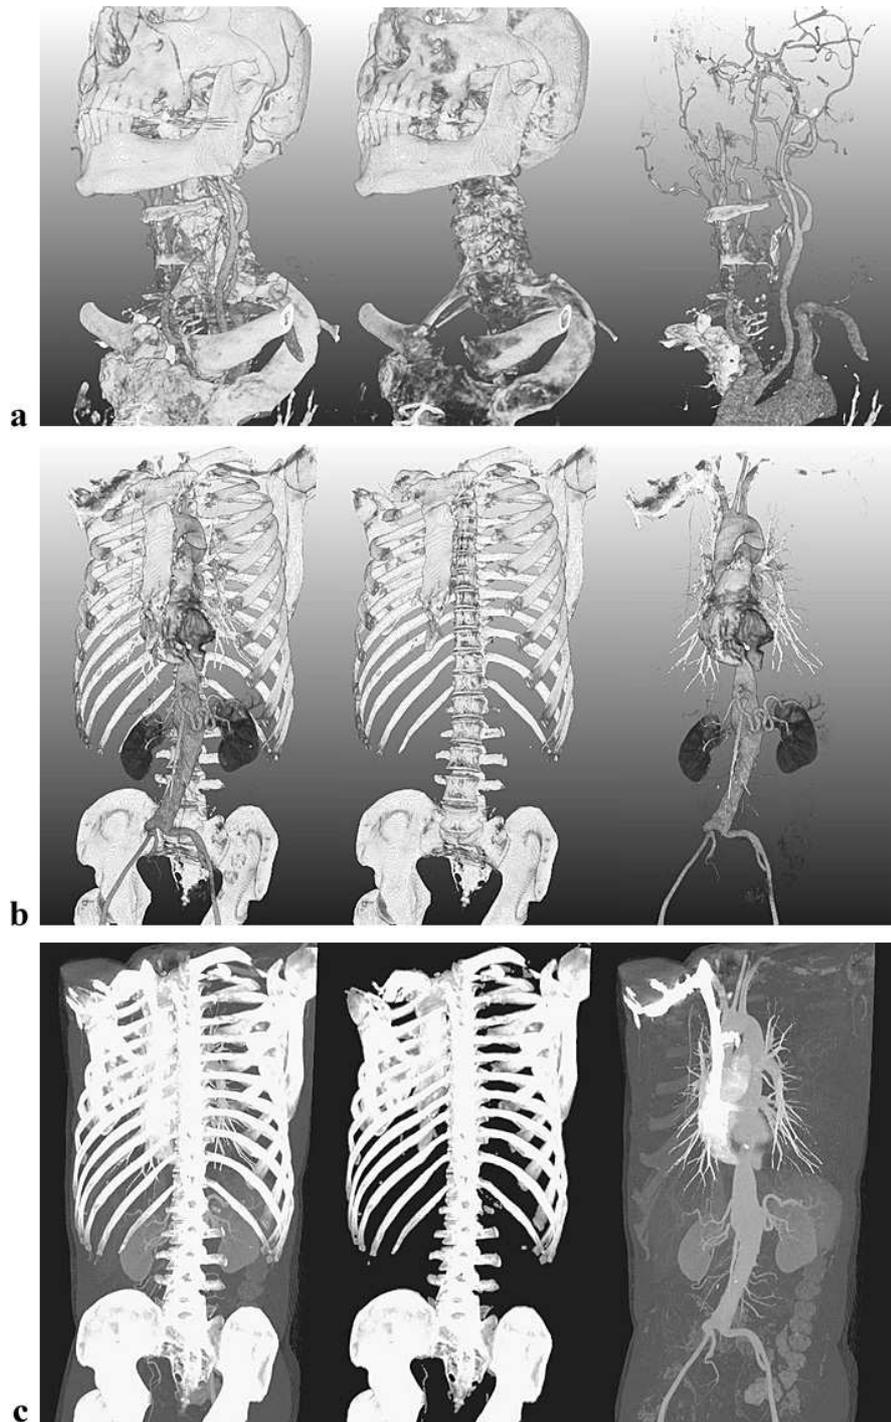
Two examples for CT bone removal performed by the proposed method. *left – center – right:* original data – bone segmentation – bone removal result. *a:* On head CTA images, bone removal is particularly difficult due to the close bone-vessel interface at the skull base. *b:* Thoracic and abdominal scan with ≈ 1000 slices. Problems are induced by bone-vessel contact and high concentrations of contrast agent. *c:* Same as *b*, but MIP instead of DVR rendering technique. (CT images courtesy of CLARA SOULIÉ, SIEMENS MEDICAL SOLUTIONS, Forchheim)
